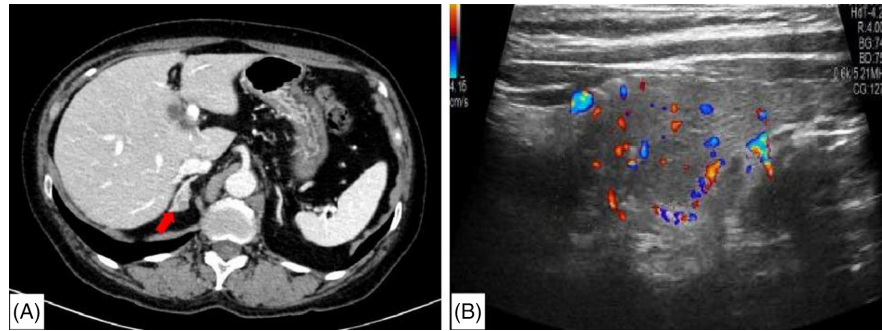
Images of adrenal contrast-enhanced CT and thyroid ultrasonography. (A) a benign nodule in the right adrenal (9 mm × 7 mm) was observed, implying the possibility of adrenal adenoma. (B) Diffusely decreased echogenicity in the whole thyroid was detected, indicating the possibility of Hashimoto's thyroiditis.
